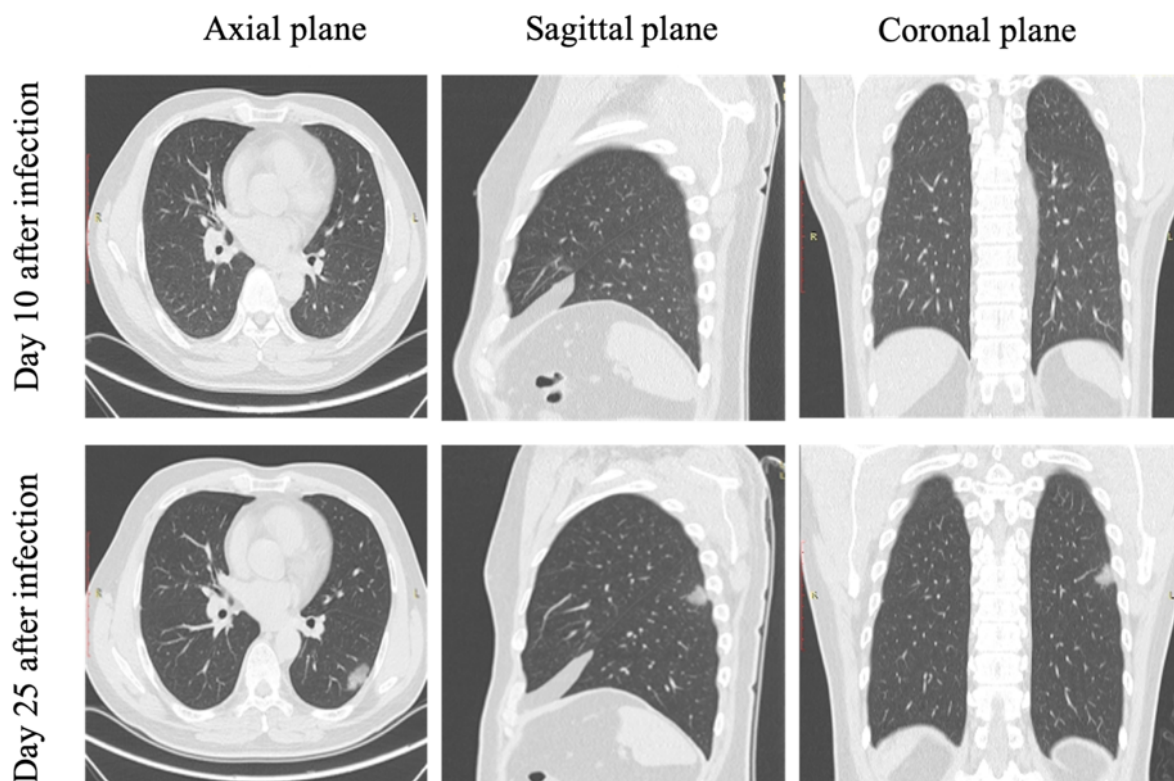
CT scan showed that 1.4 cm mass with less density was found in the 6th segment of lower lobe in the left lung. Upper panel: axial plane, sagittal plane and coronal plane of a patient 10 days after infection. Lower panel: axial plane, sagittal plane and coronal plane of a patient 25 days after infection.
